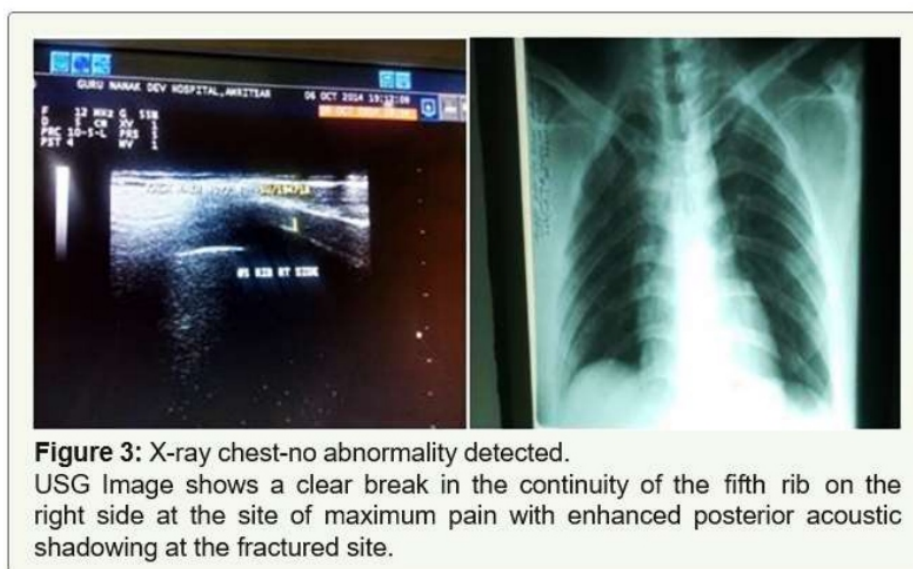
X-ray chest-no abnormality detected. USG Image shows a clear break in the continuity of the fifth rib on the right side at the site of maximum pain with enhanced posterior acoustic shadowing at the fractured site.
